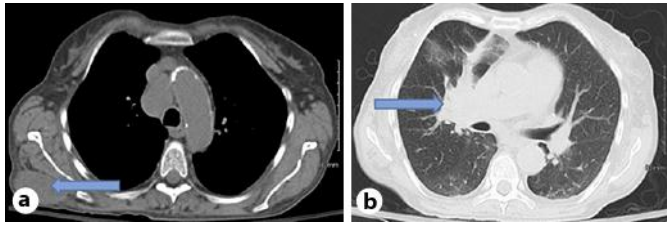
a CT of the chest revealing the right ST mass. b CT of the chest with right suprahilar mass.
